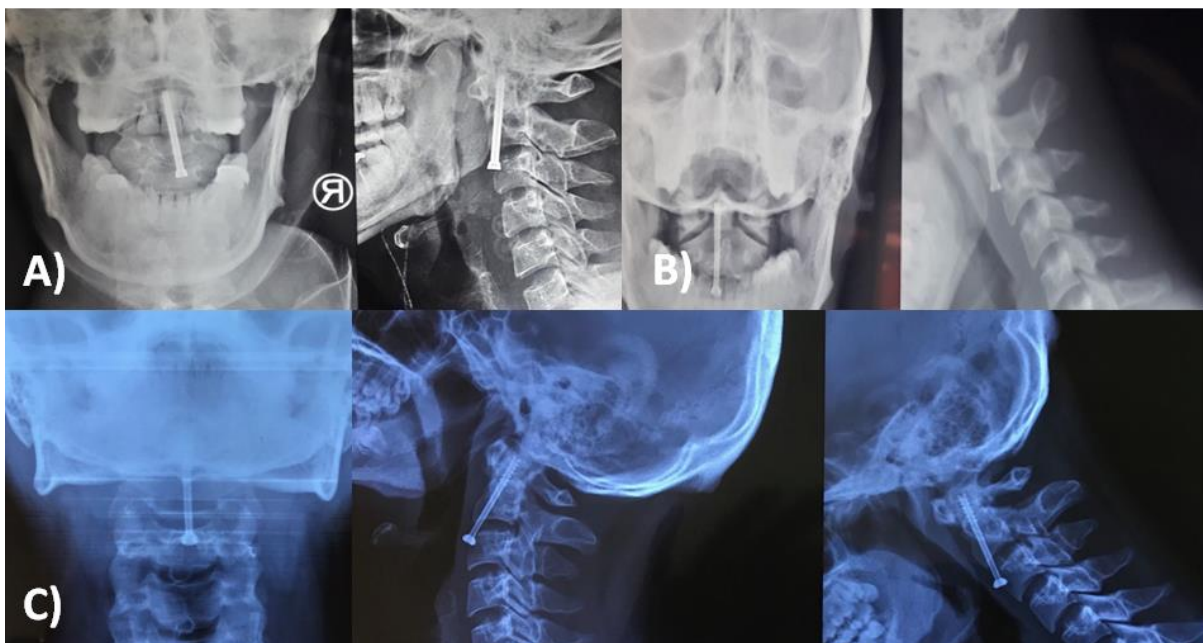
post operative images, A) Post-op X-ray of first patient, B) Post-op X-ray of second patient, C) Post-op CT scan of third patient
